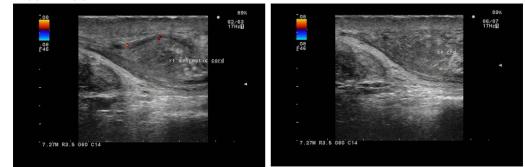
(a and b): Gray scale and colour sonogram shows spermatic cord appears bulky and heterogeneous with surrounding fat stranding. findings consistent with funiculitis.
